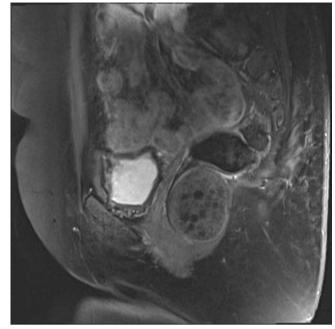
MRI of dermoid cyst. (Reused with permission of Mayo Foundation for Medical Education and Research, all rights reserved)
